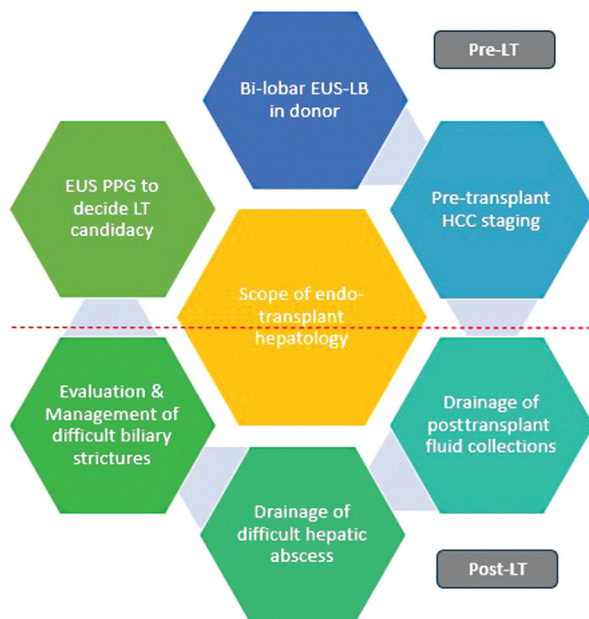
Scope of endotransplant hepatology. EUS, endoscopic ultrasound; HCC, hepatocellular carcinoma; LB, liver biopsy; LT, liver transplant; PPG, portal pressure gradient.
